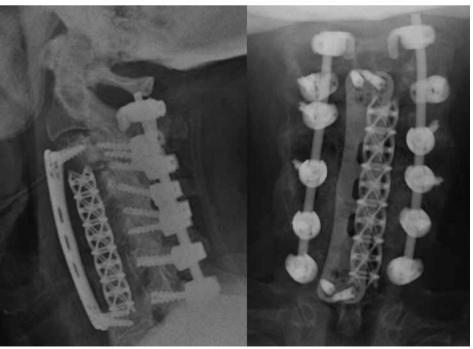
X-rays two years after the surgery.
